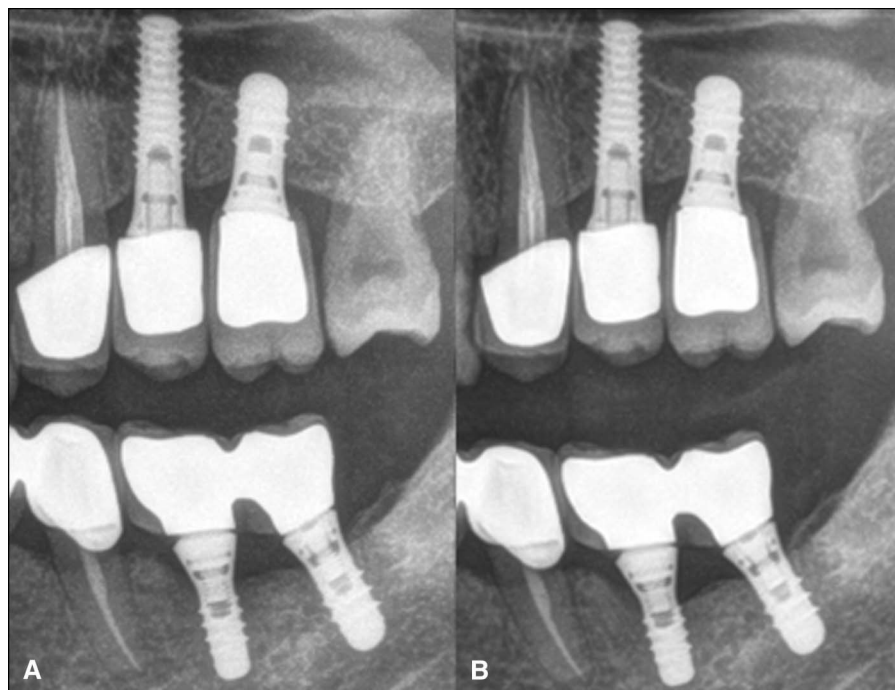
A and B, Radiographs of SLA implants after a mean observation period of (A) 26-month follow-up period and (B) 85-month follow-up periods. Note the marginal bone loss after 85 months in Figures 1B and 2B.
